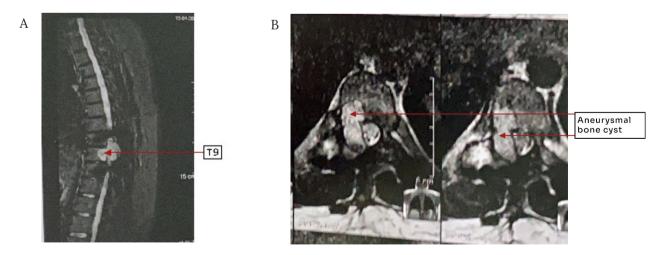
Magnetic Resonance Imaging of the patient's thoracic spine. A) Sagittal section of the thoracic spine showing hyperintense lesion in the pedicle region of T9 with spinal canal invasion and metallic artifacts in T8 and T10 compatible with pedicle screws. B) T2 axial sequence with a tumor in the pedicle and transverse process of T9 on the right with canal invasion.
